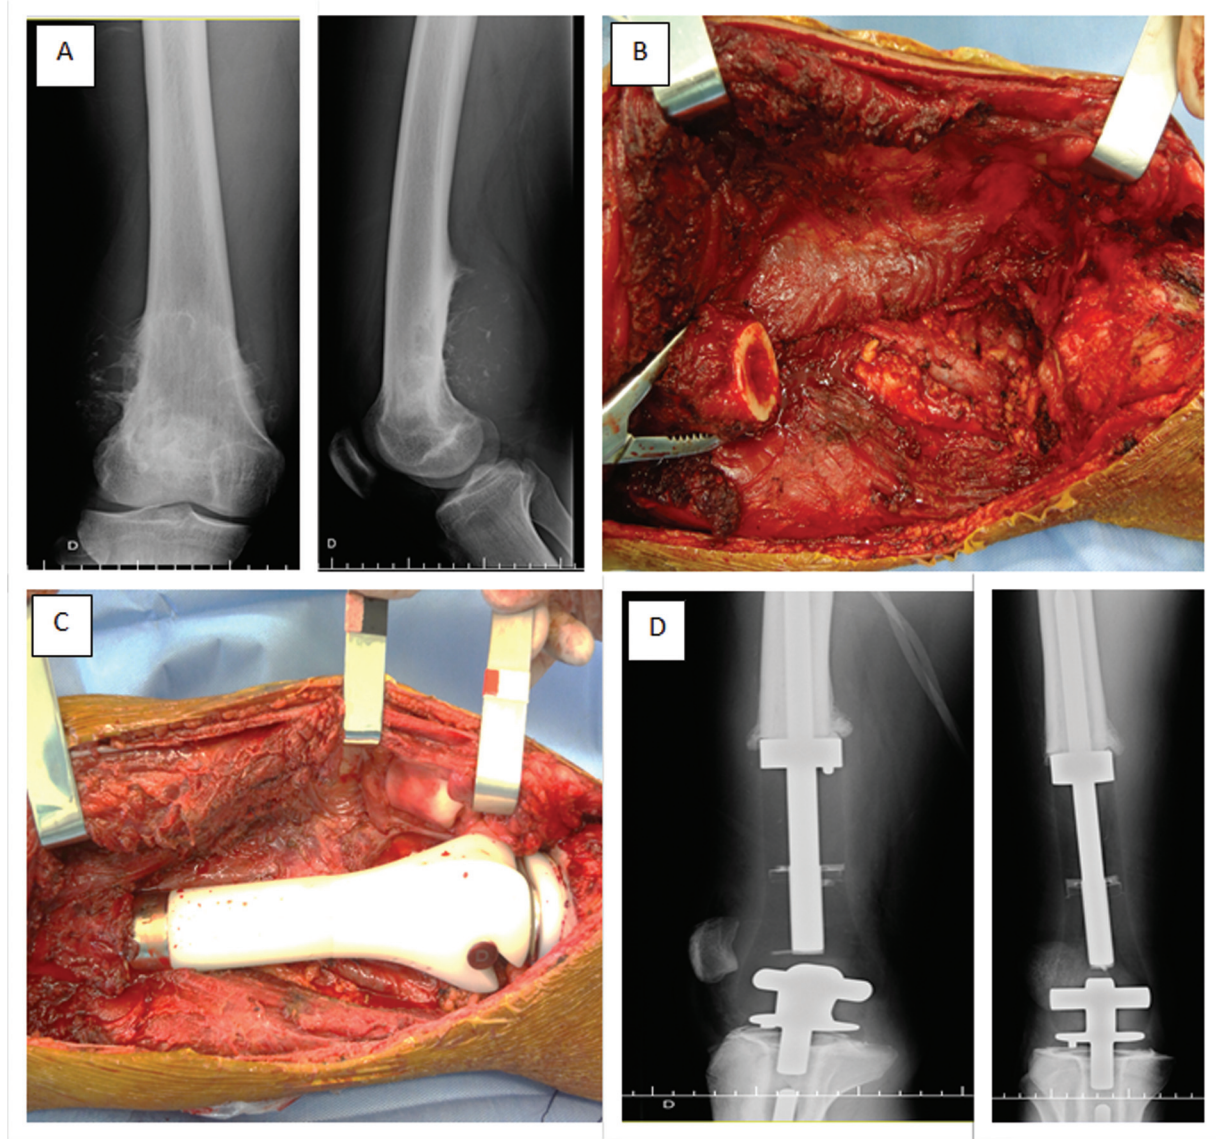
Cemented distal femur endoprosthesis with polyethylene body and titanium rod with articulated knee, custom-made. (A) Anteroposterior (AP) and profile (P) radiographs of a case of periosteal osteosarcoma of the distal femur. (B) Intraoperative imaging of bone failure. (C) Intraoperative imaging after reconstruction. (D) Anteroposterior and P radiographs after reconstruction.
